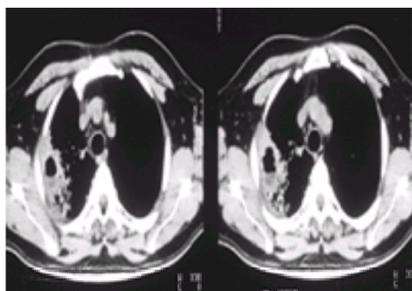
CT of a patient in whom a lung abscess was diagnosed. Note the cavitory lesion with the characteristic air-fluid level and surrounding inflammation and tissue necrosis.
